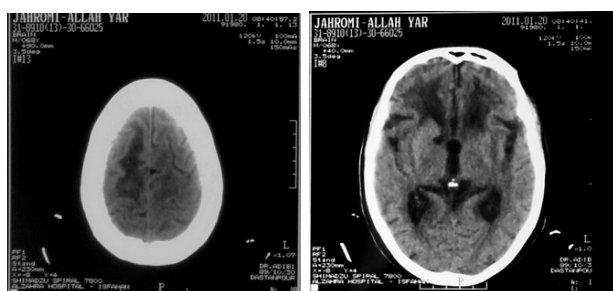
Spiral brain CT scan two weeks later
